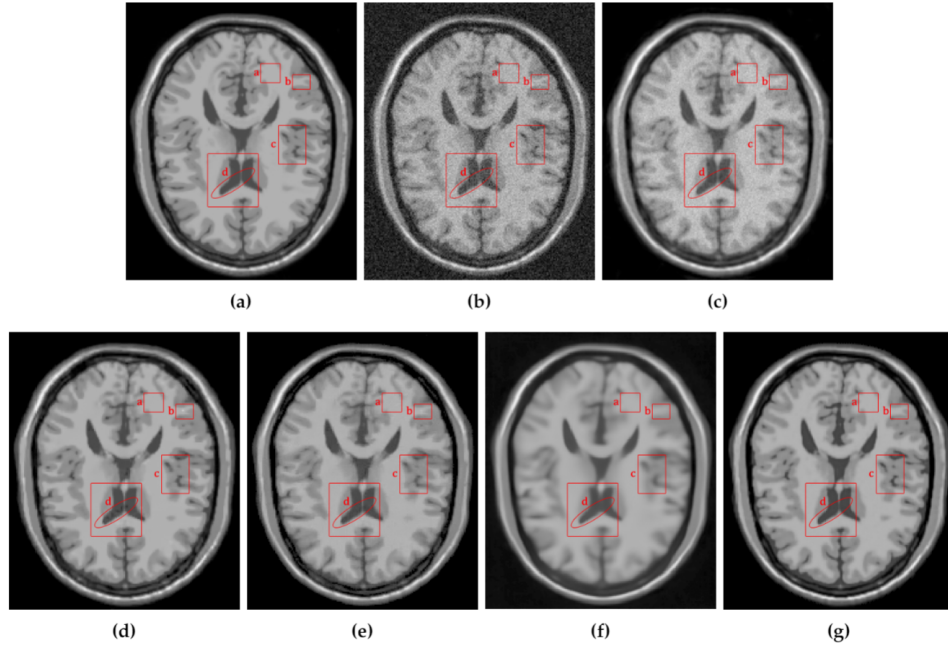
Comparison of the denoising methods on the T1w synthetic noise-free MR image corrupted with 5% Rician noise. (a) Original synthetic noise-free MR image. (b) Original image corrupted with 5% Rician noise. (c–g) Denoising results of the KSVD, PRINLM, BM4D, DnCNN, and the proposed method NLSD.
